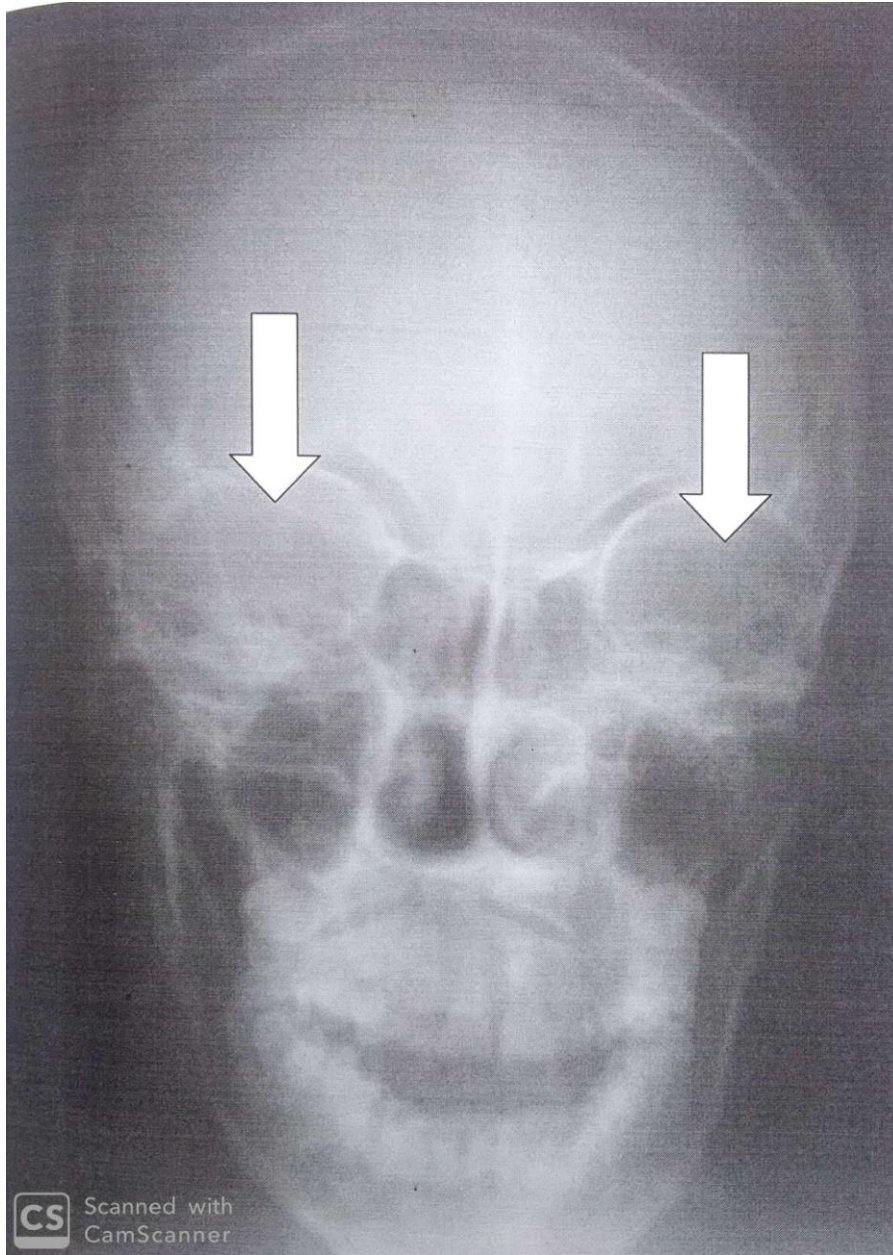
A posteroanterior view of a 31-year-old male skull radiographs with the white bold arrows pointing at the orbits.
